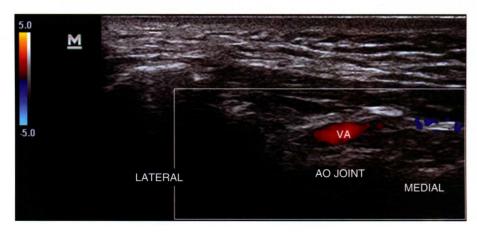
Ultrasound image demonstrating the relationship of the vertebral artery (VA) to the atlanto-occipital (AO) joint.
